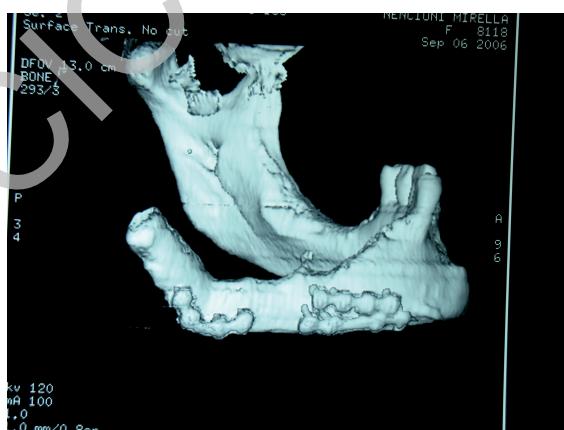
CT reconstruction of lower jaw after surgery
